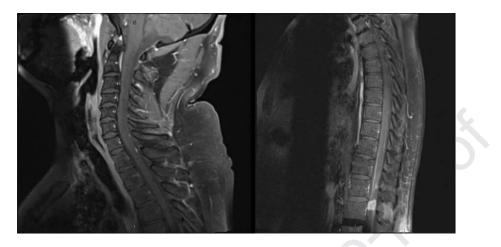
MRI T1 with gadolinium enhancement sagittal cervical left side, thoracic right side showing again multiple intadural, intraspinal drop metastasis
